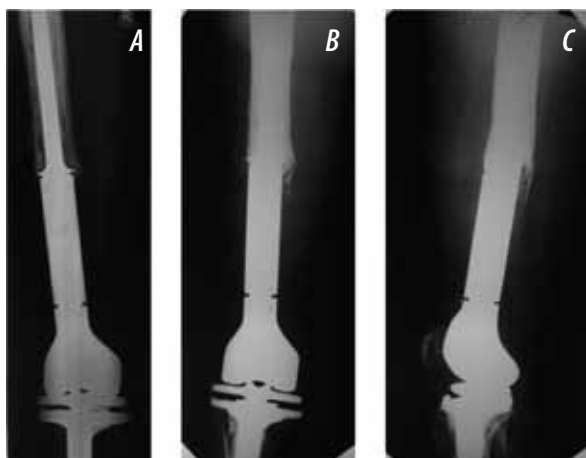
A — photoprint of the radiograph of the patient G. — aseptic loosening of the stem of knee joint endoprosthesis, produced by Stryker; B, C — photoprints of radiographs of the patient G. — a state after repeated endoprosthesis replacement of a knee joint
